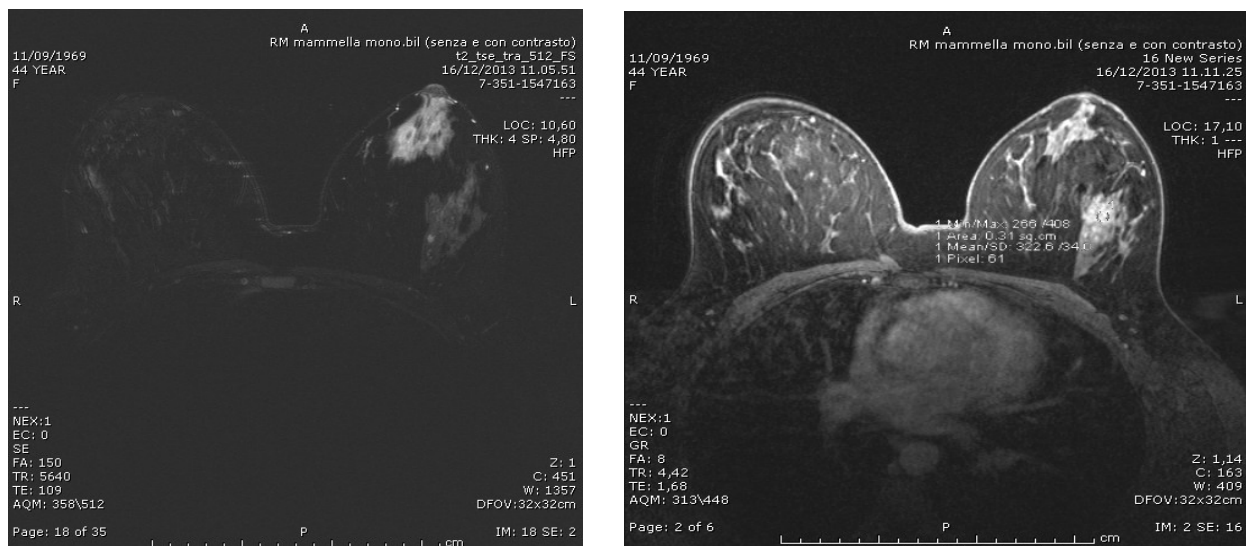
MRI breast scan (left, T2w; right T1w+contrast)
